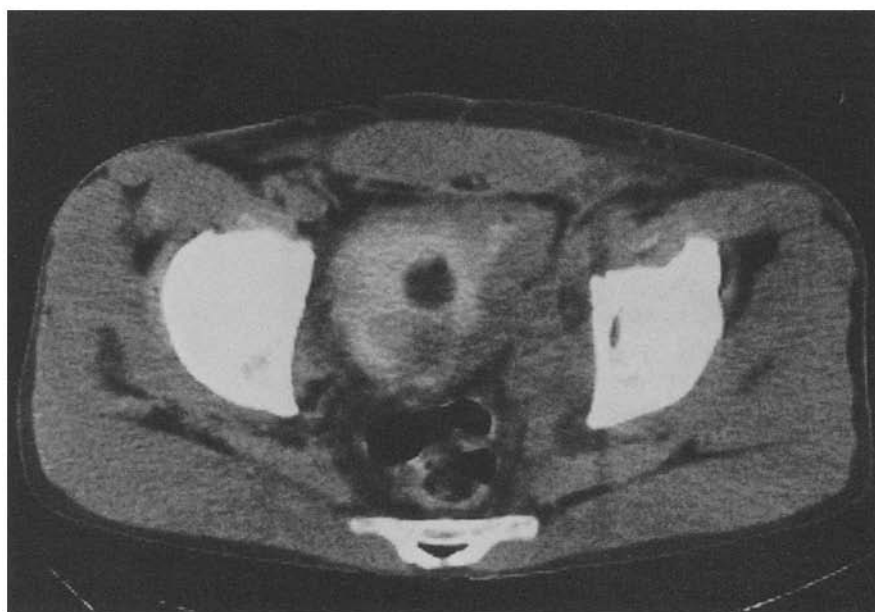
The CT scan of case 4 after superior gluteal artery infusion chemotherapy showed reduction in the size of the tumor; however, infiltration of urine into the retroperitoneal cavity due to necrosis of the tumor infiltrating into the pelvic wall was observed
